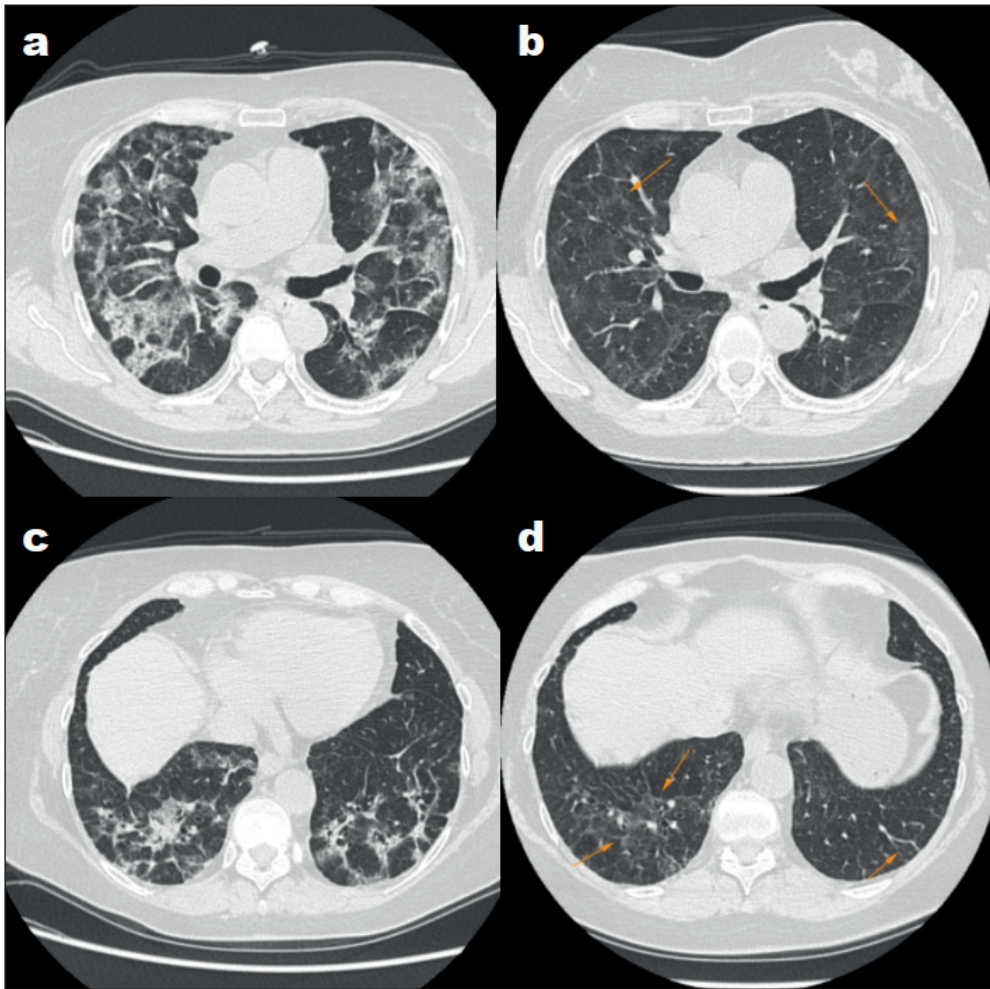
Patient 4. Important regression of extensive, diffused crazy paving signs, halo signs and consolidations at baseline CT (a, c), in a female patient with obesity and comorbidities. Persistence of important residual GGOs and fibrotic lines (arrows) in the follow-up CT (b, d).
